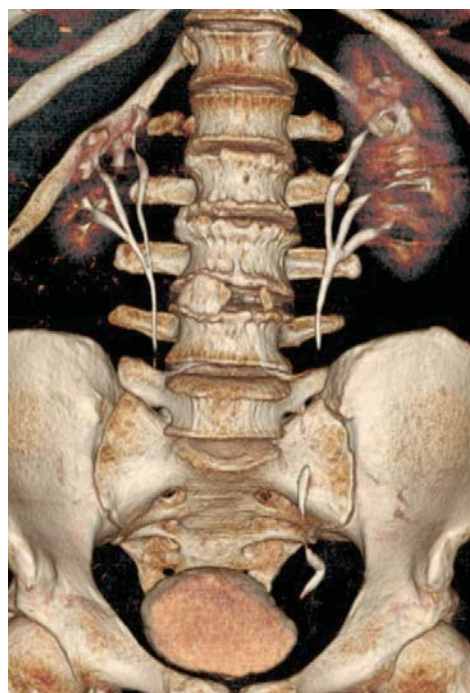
Computed tomography-urography presenting bilateral triple renal pelvis. In both kidneys, three separate renal pelvises drain separate calyces. The hypoplastic right kidney.
